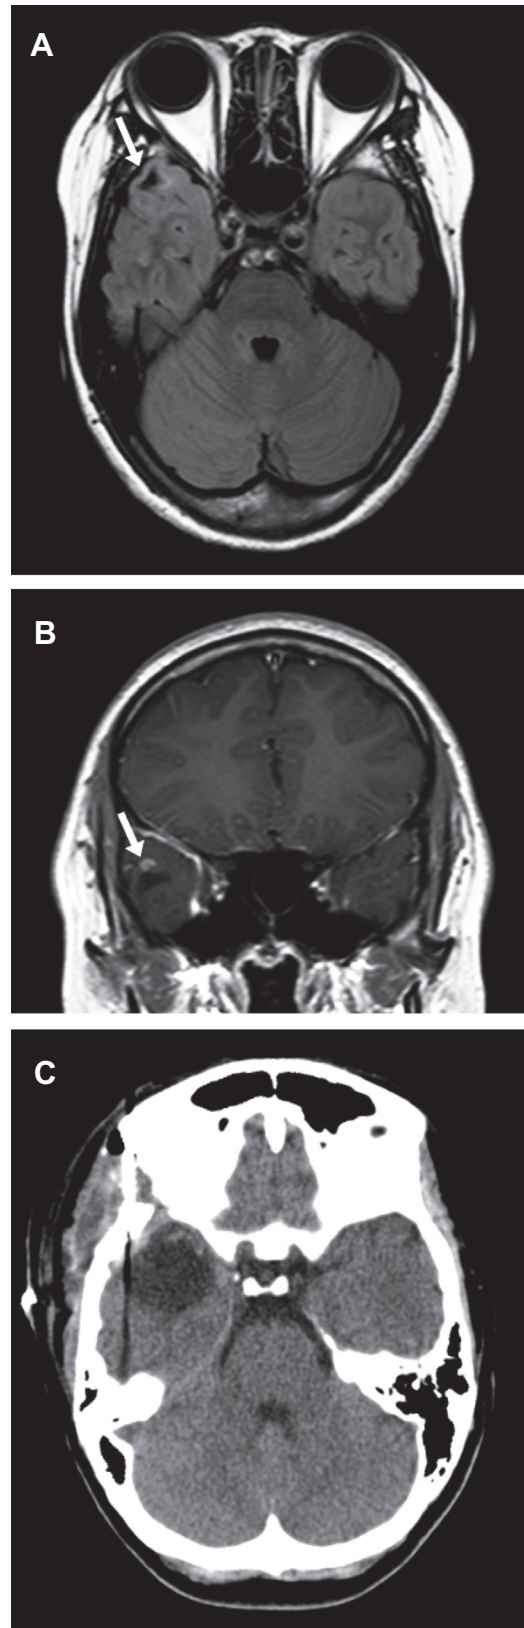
Neuroimaging of the patient. (A) Fluid-attenuated inversion recovery image. (B) Gadolinium-enhanced image. (C) Computed tomography of the brain after lesionectomy. In A, a lesion with low signal intensity (arrow), partly rimmed by high signal striae, is visible. In B, a peripheral area of the lesion is enhanced (arrow).
